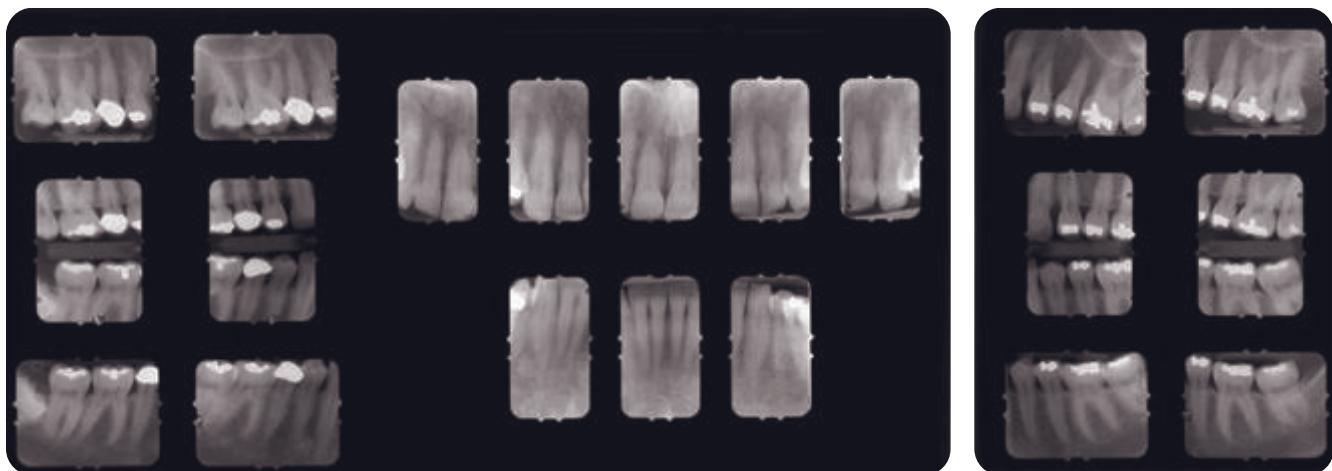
Pretreatment full mouth radiographic series.
